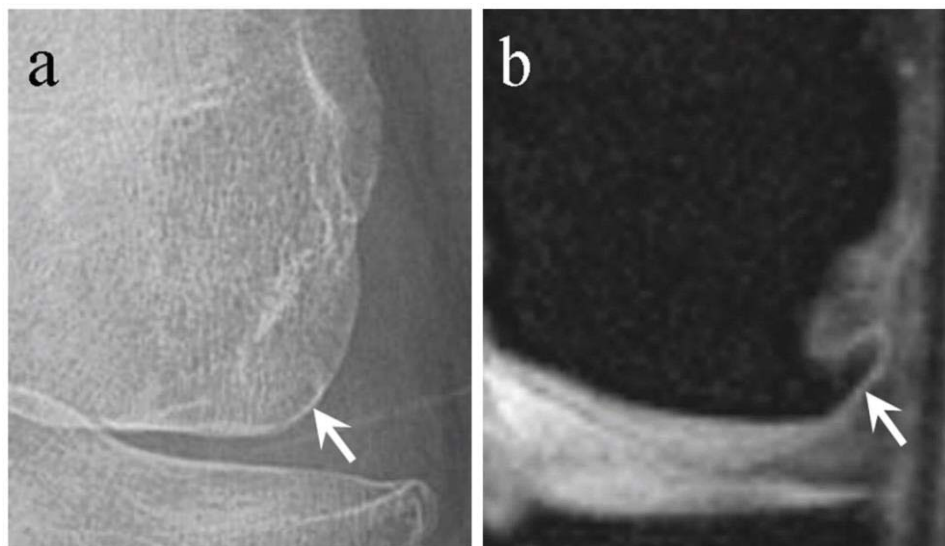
Example of an osteophyte that was not visible on radiographic but was on MRI
